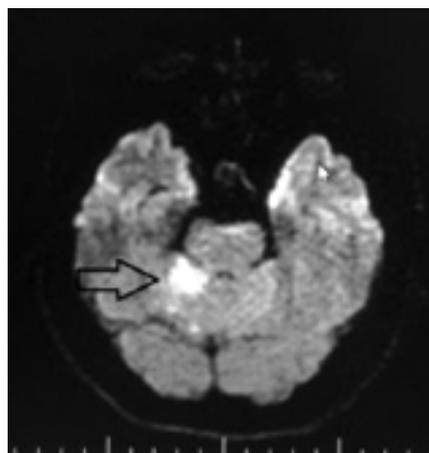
diffusion restriction in MRI - ischemia area shown by arrow in the cerebellum
